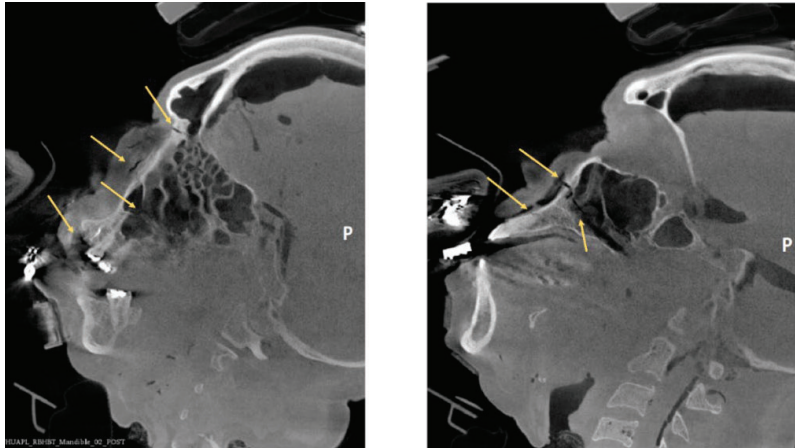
Post-test μ CT of a mid-sagittal maxilla impact (BMP_02) showing facial fractures
